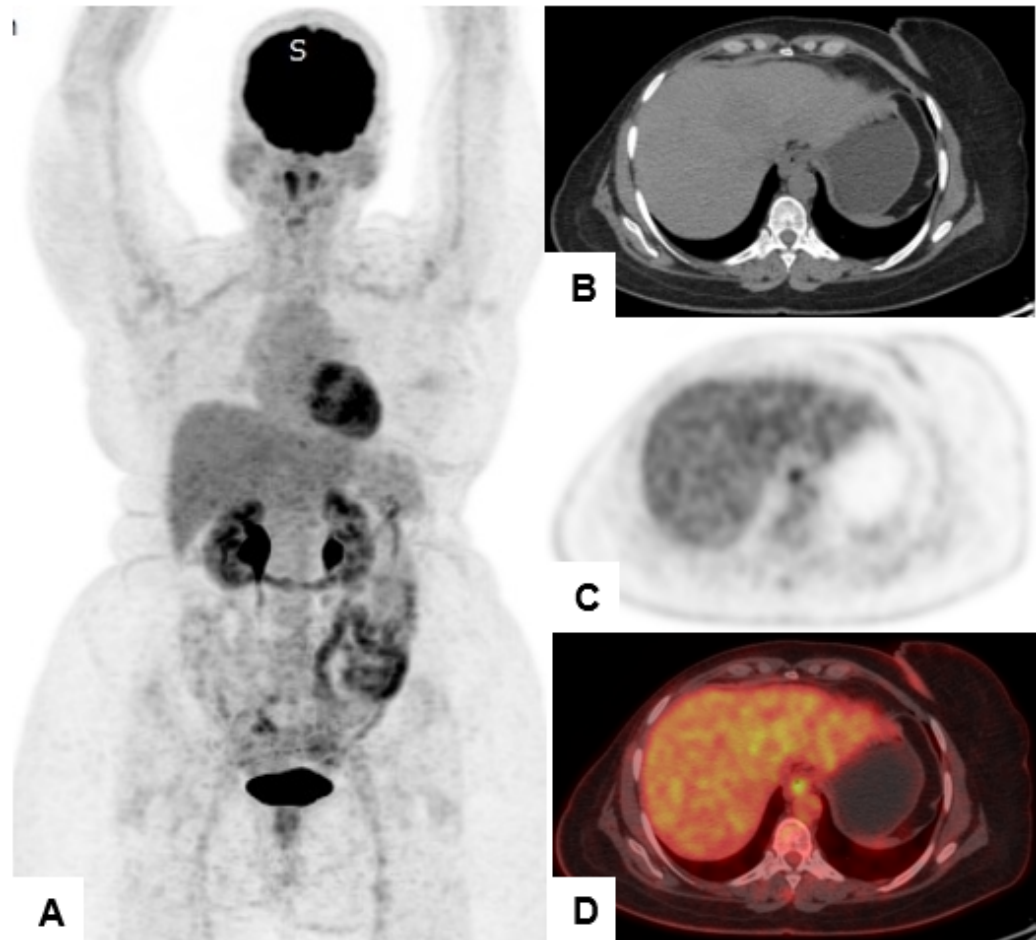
Standard-time-point 18F-FDG PET/CT images showing no definitive hepatic lesion. (A) Maximum-intensity-projection FDG-PET image; (B) axial CT image; (C) corresponding axial PET image; and (D) fused PET/CT image acquired 45 minutes after injection. Physiological hepatic uptake is present.
